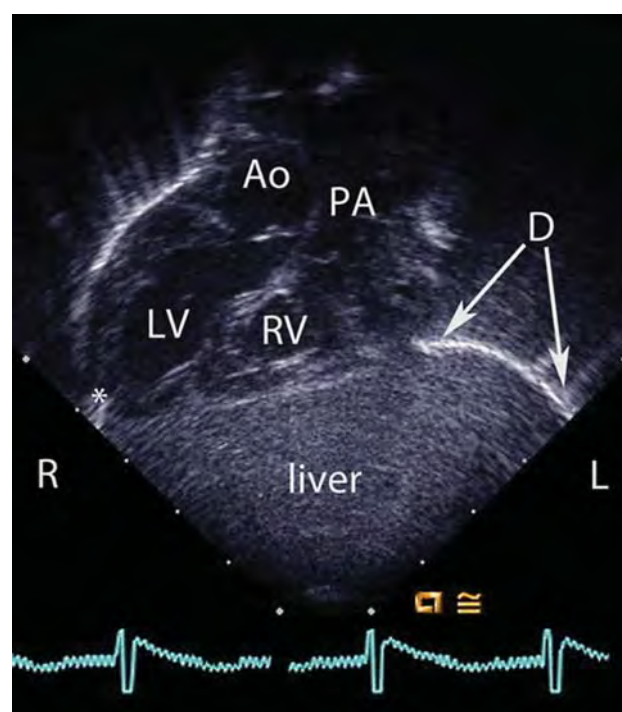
Subxiphoid coronal echocardiographic image showing the cardiac apex (asterisk) pointing rightward (R) with a right-sided left ventricle (LV) and a right-sided right ventricle (RV) giving rise to the aorta (Ao) and main pulmonary artery (PA), respectively. Notice the diaphragm (D) is intact on the left side (L) of this neonate.
